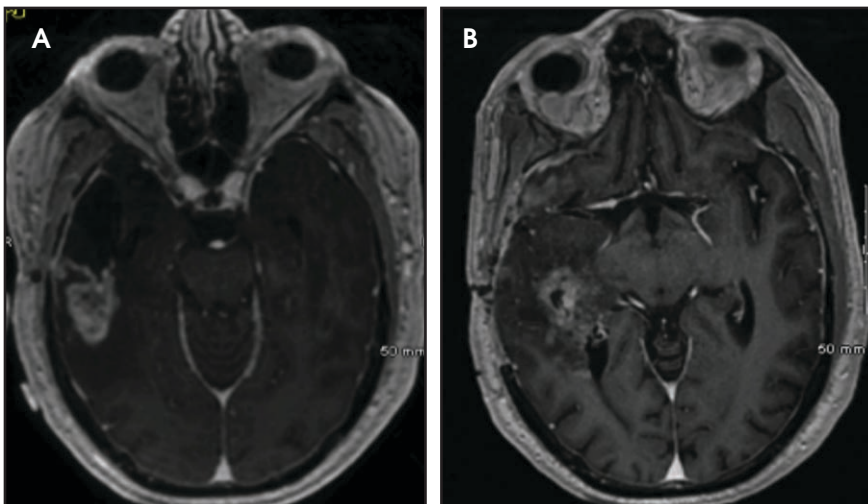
Follow-up T1-weighted cranial MRIs showing local recurrence at the initial site following a second round of radiation and temozolamide therapy (A) and then after an additional 12 months of chemotherapy and hospitalization for meningitis (B).
